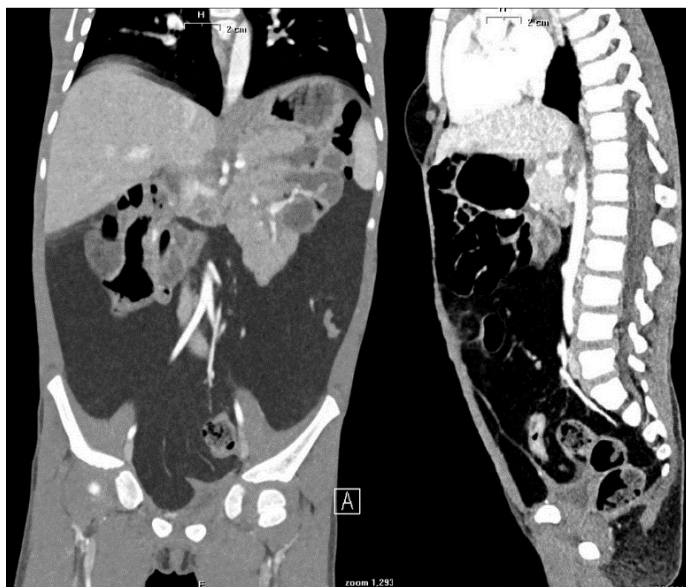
Abdominal CT scan - coronal and sagittal sections.
